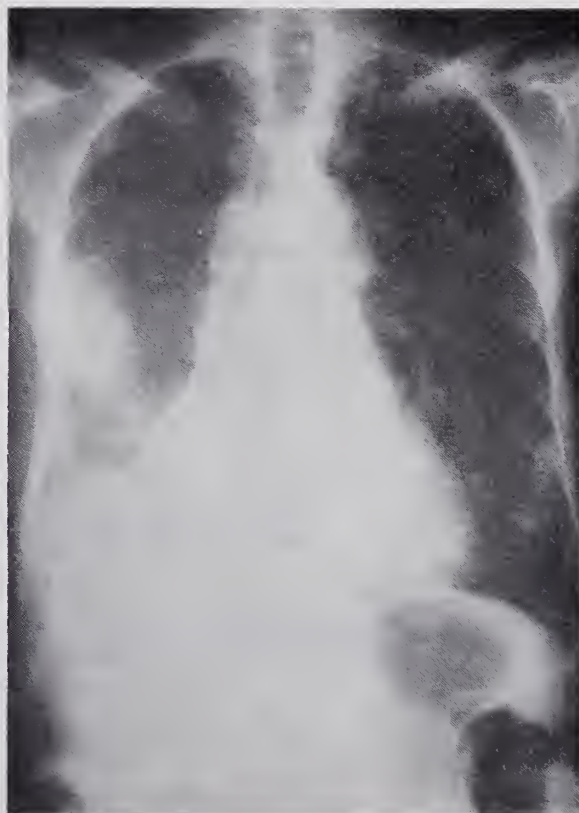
Chest x-ray May 1976, after 11 months of treatment, showing progressive disease bilaterally.
